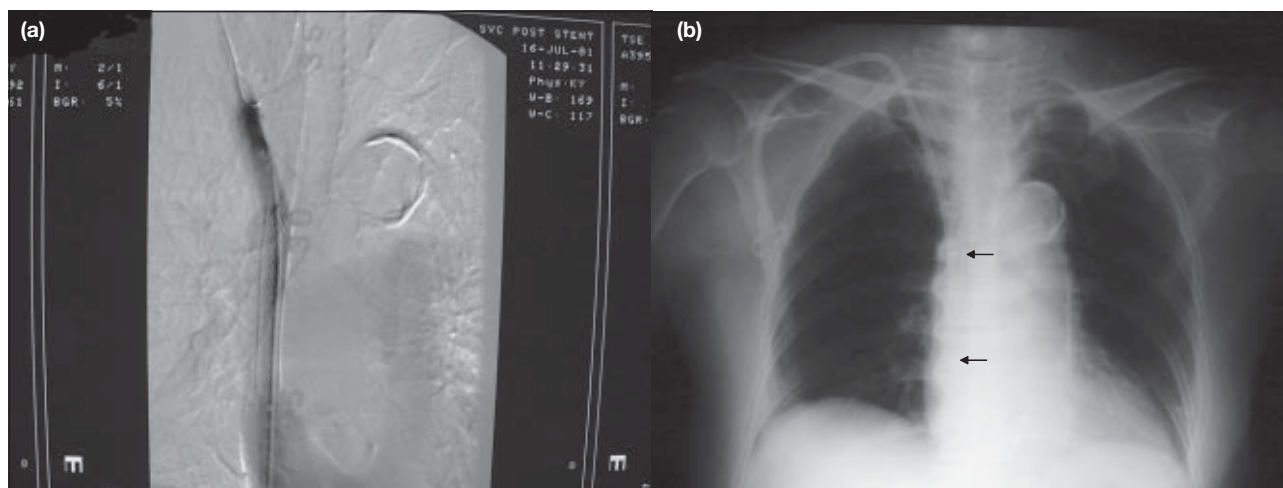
(a) Superior vena cavogram via 5-French H1 catheter after superior vena cava (SVC) stenting. The safety guidewire has been pulled to the right brachiocephalic vein before stenting. (b) Chest radiograph after SVC stenting and insertion of PermCath. The tip of the PermCath is at the junction of the SVC and the right atrium; SVC stent is noted in place (arrows)
